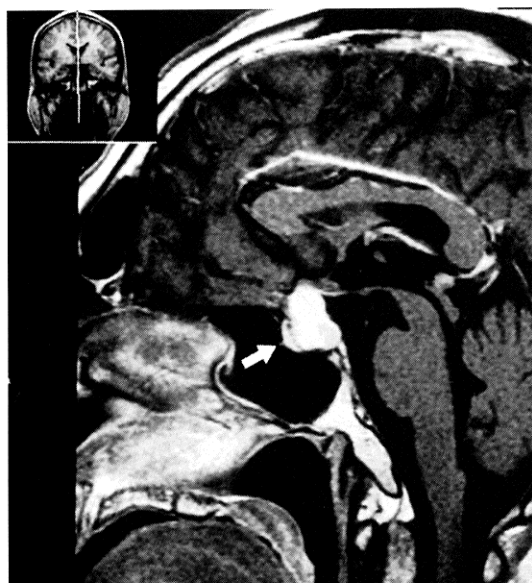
Sagittal T₁-weighted MR images after Gd-DTPA administration showing enhancement of the partially compressed pituitary gland (arrow) but not the lesion.
